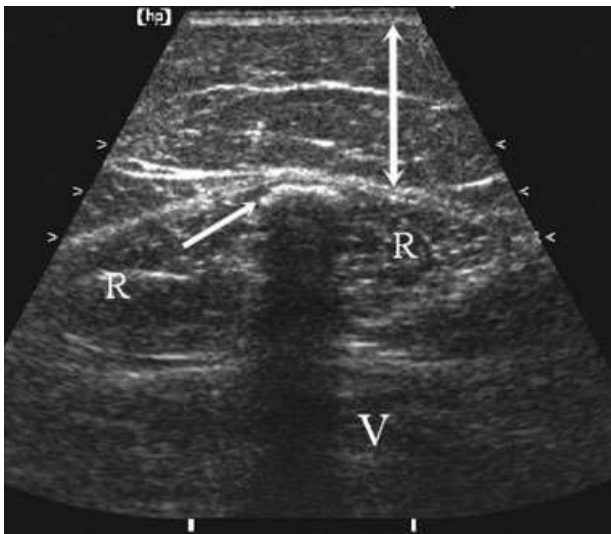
Muscle ultrasound investigation of the quadriceps muscle, at two thirds along the line from the anterosuperior iliac spine to the patella of a 15-year-old, who had suffered from juvenile dermatomyositis with a monocyclic course when she was 2 years old. One year after diagnosis she developed severe subcutaneous and intramuscular calcifications, especially in the right leg, causing a flexion contracture of her right knee. Muscle ultrasound of the quadriceps muscle in a transverse plane revealed multiple subfascial plaques of calcification, visible as echogenic structures casting a shadow (white arrow). R, rectus femoris; V, vastus intermedius; double arrow, subcutaneous tissue.
